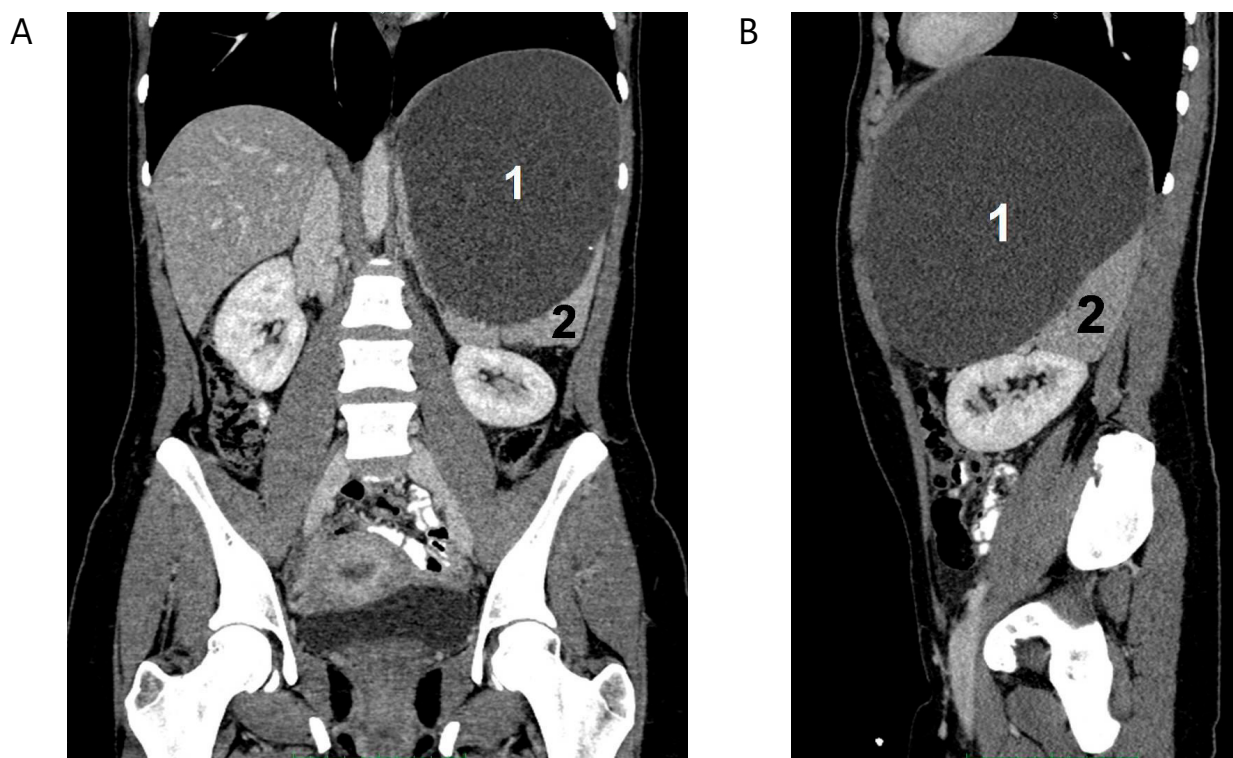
(A) Case no. 1. Abdominal CT with visible huge splenic cyst (p-a view). Designation: 1—cyst, 2—splenic parenchyma; (B) Case no.1. Abdominal CT with visible giant splenic cyst (lateral view).
